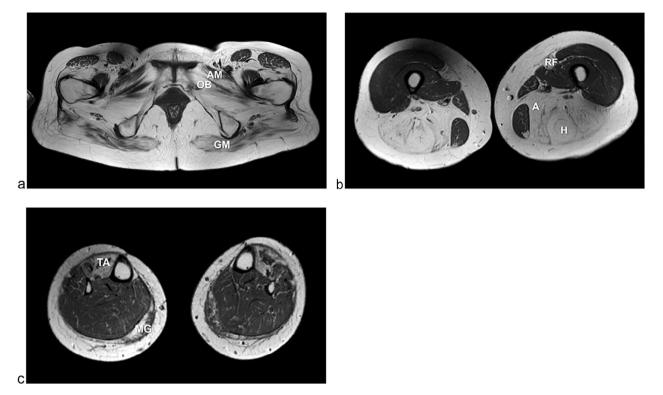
T1 axial MRI sections showing increased signal intensity in (A) the gluteus maximus (GM), adductor magnus (AM) and obturatorius externus (OB) muscles, (B) in the hamstring (H), adductor (A) and rectus femoris (RF) muscles, and (C) in the tibialis anterior (TA) and medial gastrocnemius (MG) muscles.
